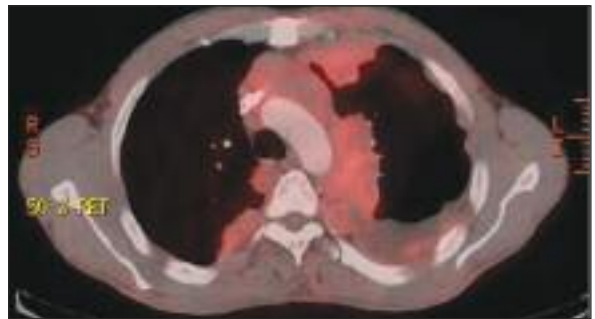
¹⁸F-FDG PET/CT fusion images demonstrate an anterior mediastinal partially calcified mass (maximal standard uptake value [SUV max: 4.42]).
